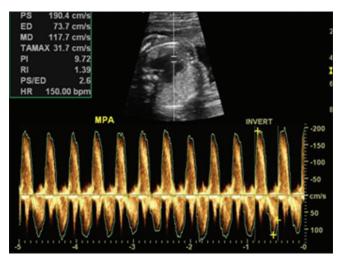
Spectral Doppler: High velocities across pulmonary valve annulus. Velocity 190.4 cm/sec
